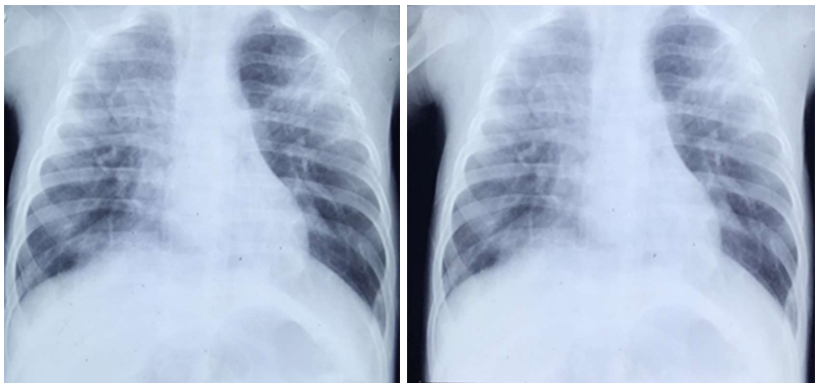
Chest X-ray of CD8+ deficient child showing bilateral infiltrates.
